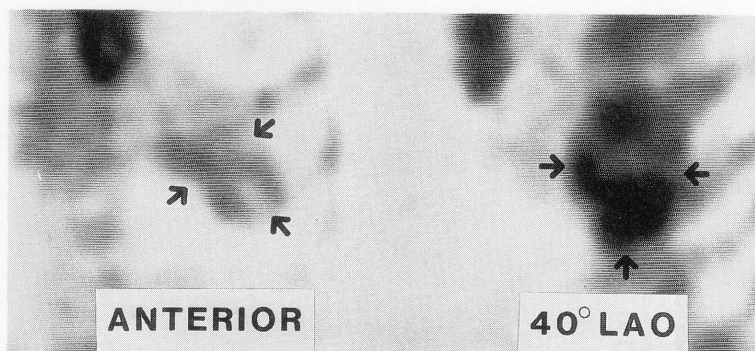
Planar ^{99m}Tc -PYP scintigrams showing a diffuse cardiac uptake (arrows).
